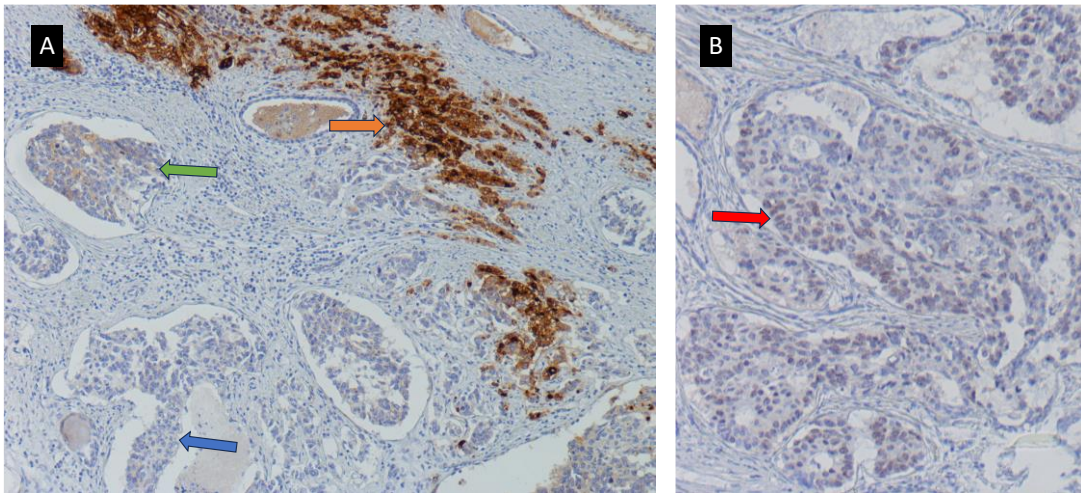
IHC analysis a patient with high tumor heterogeneity and SOX-2 expression. Figure A shows the different coexistent patterns of PSMA expression: PSMA 3+ is indicated by orange arrow, patterns with low PSMA expression (PSMA 1+) are indicated by the green arrow, and the blue arrow indicates area with no PSMA uptake (PSMA 0). On the right, Figure B shows the expression of SOX-2 in prostate cancer cells of the same patient with high PSMA heterogeneity.
